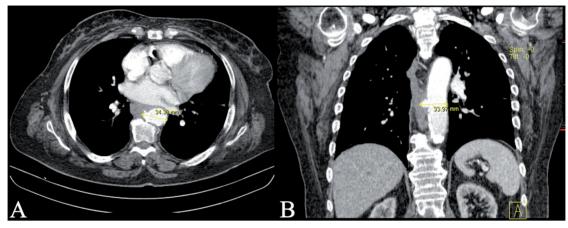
Cervical-thoracic computed tomography revealed a circumferential wall thickening in the middle esophagus with surrounding fat densification without cleavage plane with the descending aorta, which had irregular contour and 34mm aneurysmal dilation – (A) axial view, (B) coronal view.
